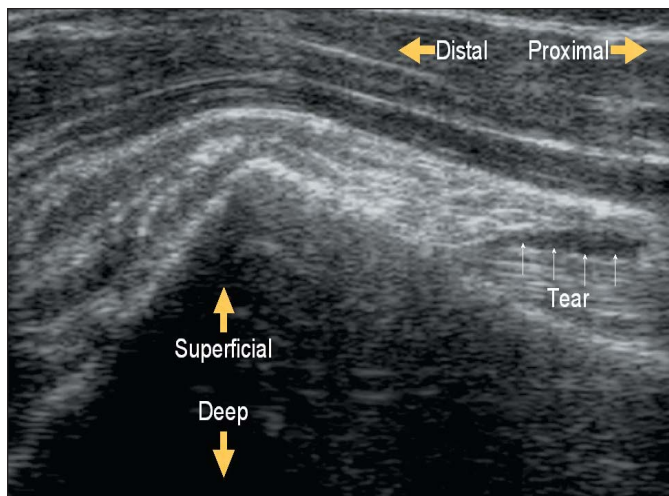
Tear of long head biceps tendon in a 70 year-old patient (ultrasound image before PRP treatments).
